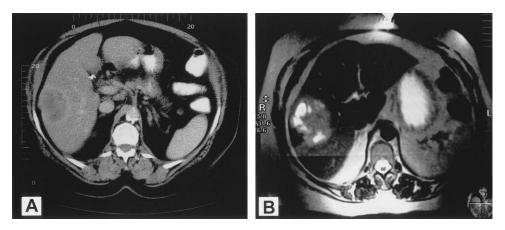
Preoperative imaging observations. Abdominal computed tomography (CT) (A) reveals a heterogeneous solid mass in the right lobe of the liver. T1-weighted magnetic resonance imaging (MRI) (B) indicates multiple regions of fluid-like signals within the lesion representing cystic components or necrosis. There is dilatation of the common bile duct (CBD) to 1.8 cm.
